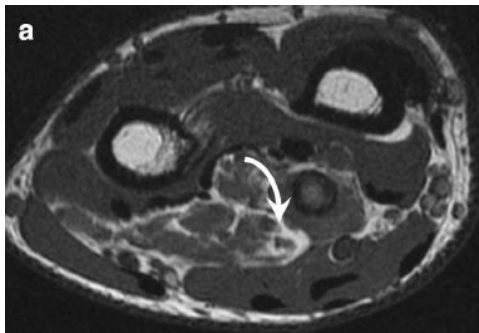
T1-weighted MRI of an intramuscular hemangioma [23]
